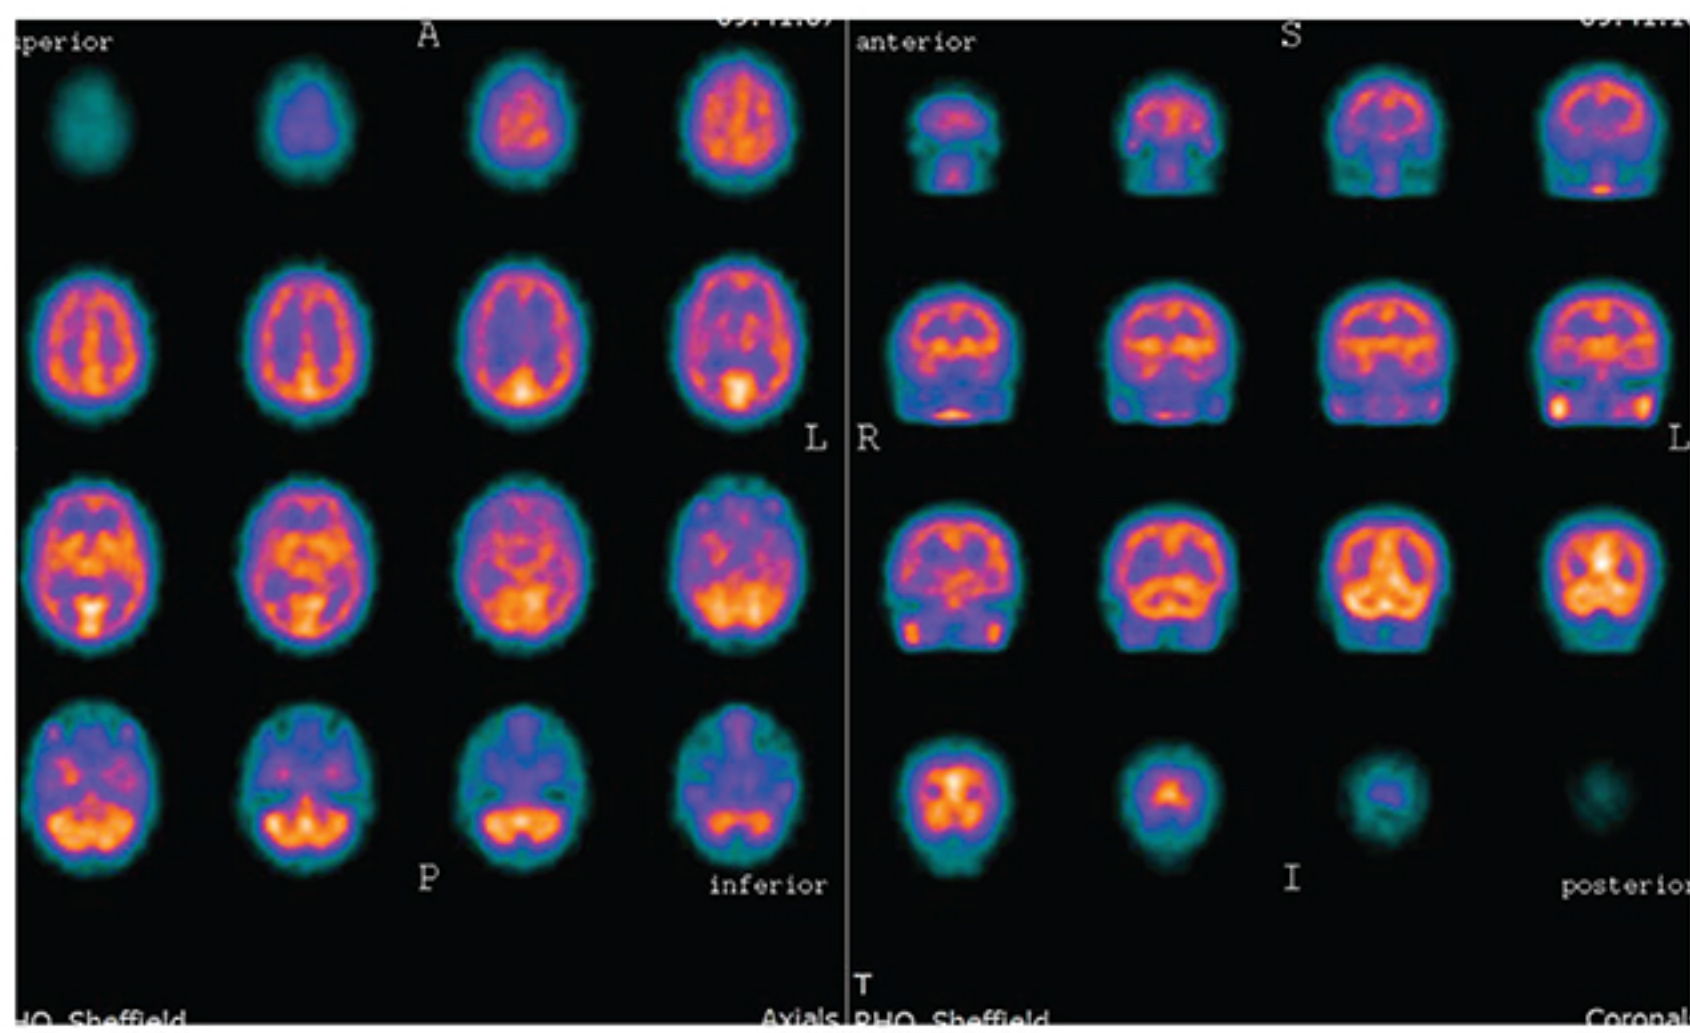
Unequivocal ictal SPECT
